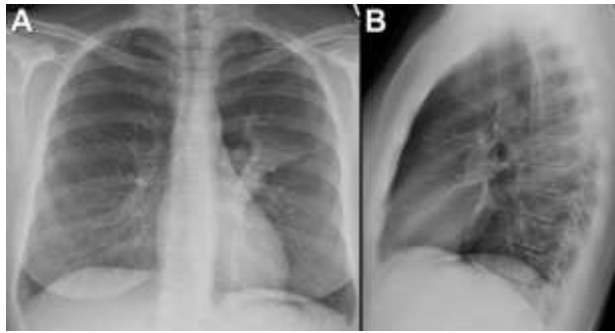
Frontal (A) and lateral (B) chest radiography obtained around the time the patient was diagnosed with COVID-19.
